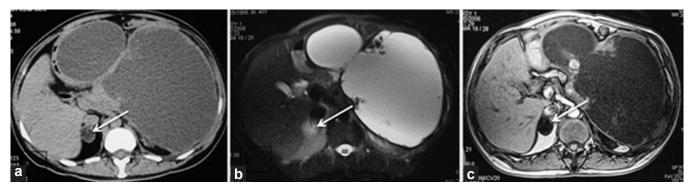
Adrenal adenoma: Axial CT image in (a) shows hypodense fat containing mass (arrow) in the right adrenal. (b) The mass is hyperintense (arrow) on fat-saturated axial T2-weighted images although the rest of the fat gets suppressed. (c) The mass shows signal drop (arrow) on out-of-phase T1 axial image
